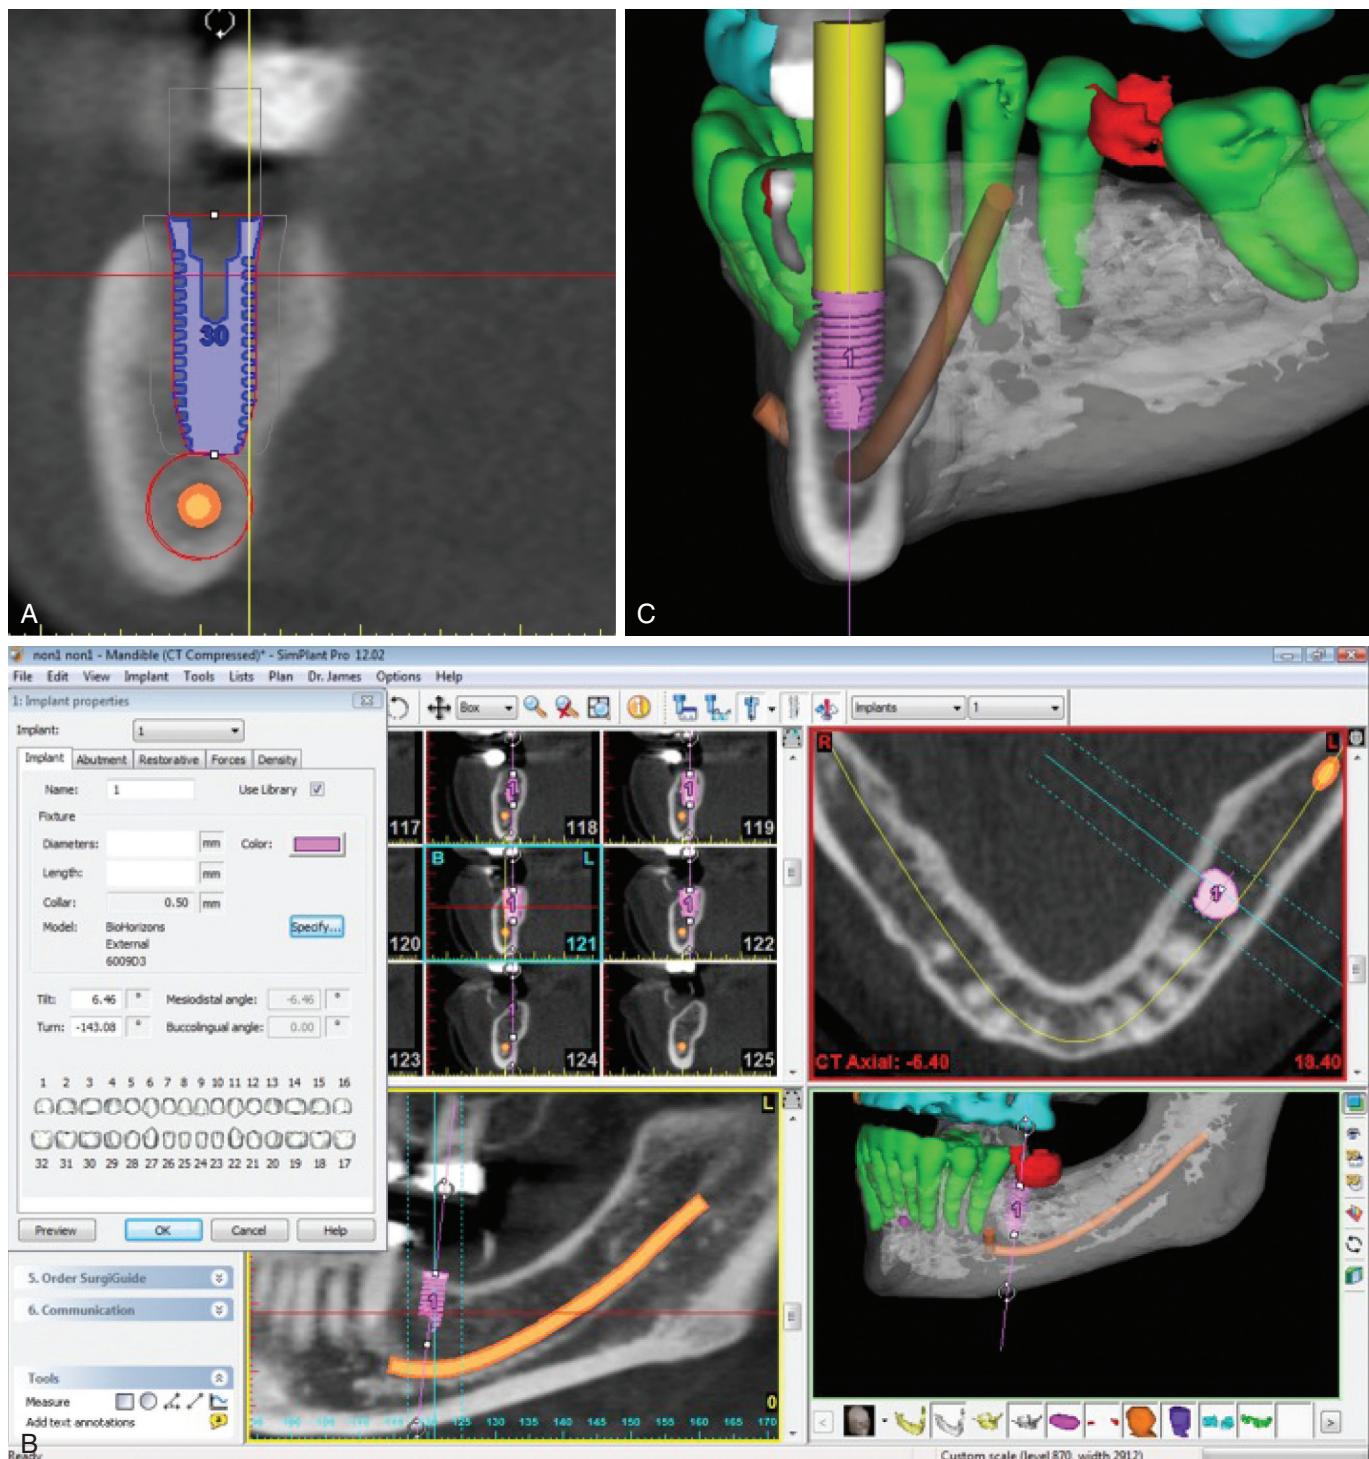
(A) CBCT images have no magnification and are 1:1 and can be relied upon for measurements that approximate vital structures. (B–C) Third-party interactive software programs showing implant placement via integrated software program.
